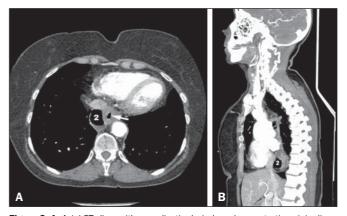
A: Axial CT slice, with a mediastinal window, demonstrating air in diverticulum 2 and in the esophageal lumen (arrow). B: Reformatting in the sagittal plane, showing the posterior position of diverticulum 2.
